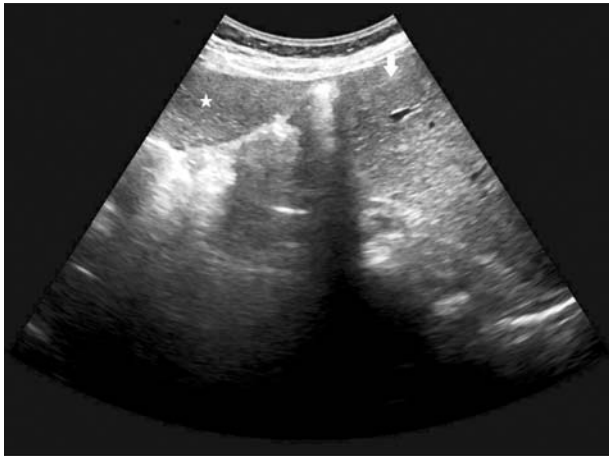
Abdominal ultrasonography – sagittal scan: high echoic soft tissue area (star) in subhepatic space with distinct margins and uniform echo with suspected connection to the right liver lobe (arrow)
